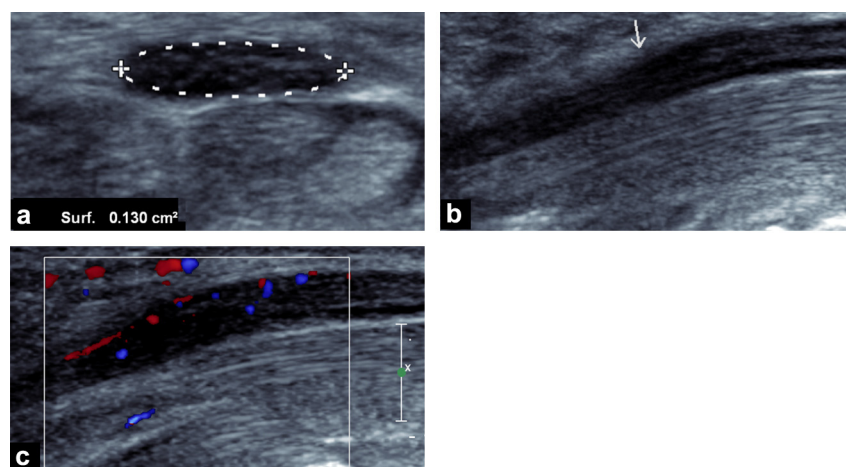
Ultrasound signs of nerve distress in a patient with carpal tunnel syndrome confirmed by electromyogram. a: cross-sectional area of the median nerve (dots) measuring 13 mm^2 with hypoechoogenicity of the nerve; b: longitudinal section shows increased diameter proximal to the entrance to the carpal tunnel (arrow); c: Doppler ultrasound in color mode shows intra-neural hyperemia.
